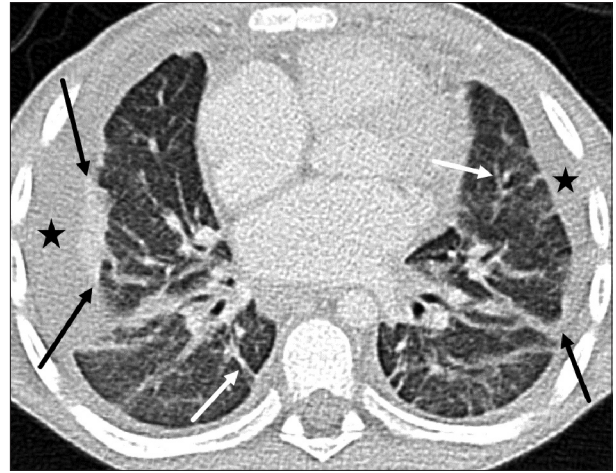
Axial chest computed tomography image of a 7-year-old male with chronic eosinophilic pneumonitis shows peripheral predominant airspace disease (black arrows) with interstitial thickening (white arrows) and pleural effusions (black stars)
